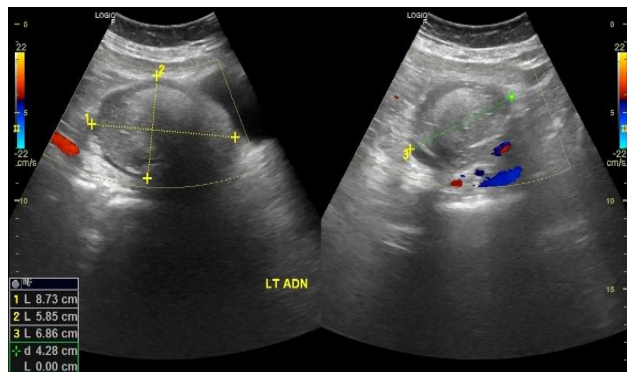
Ultrasound image of left ovarian cyst.
